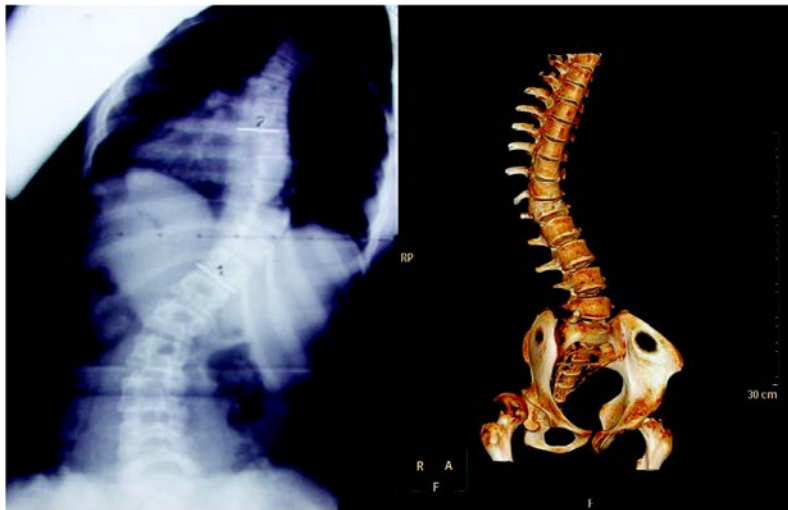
Scoliosis as seen in X-Ray and CT-Scan
